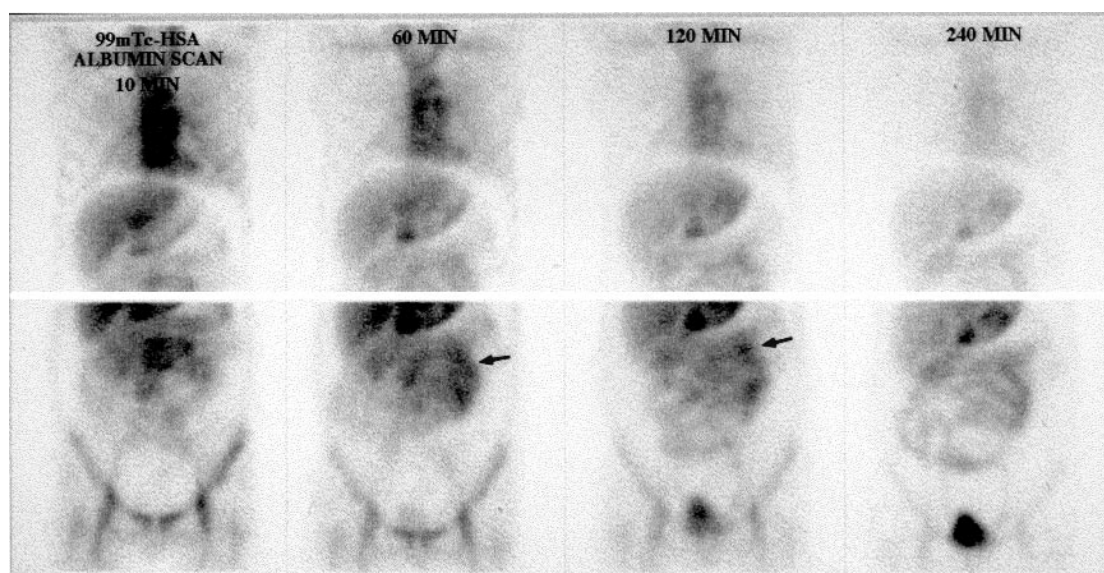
^{99m}Tc-human serum albumin scintigraphy shows protein loss from small bowel (jejunum). Serum albumin was shown to leak into jejunum (arrow).
